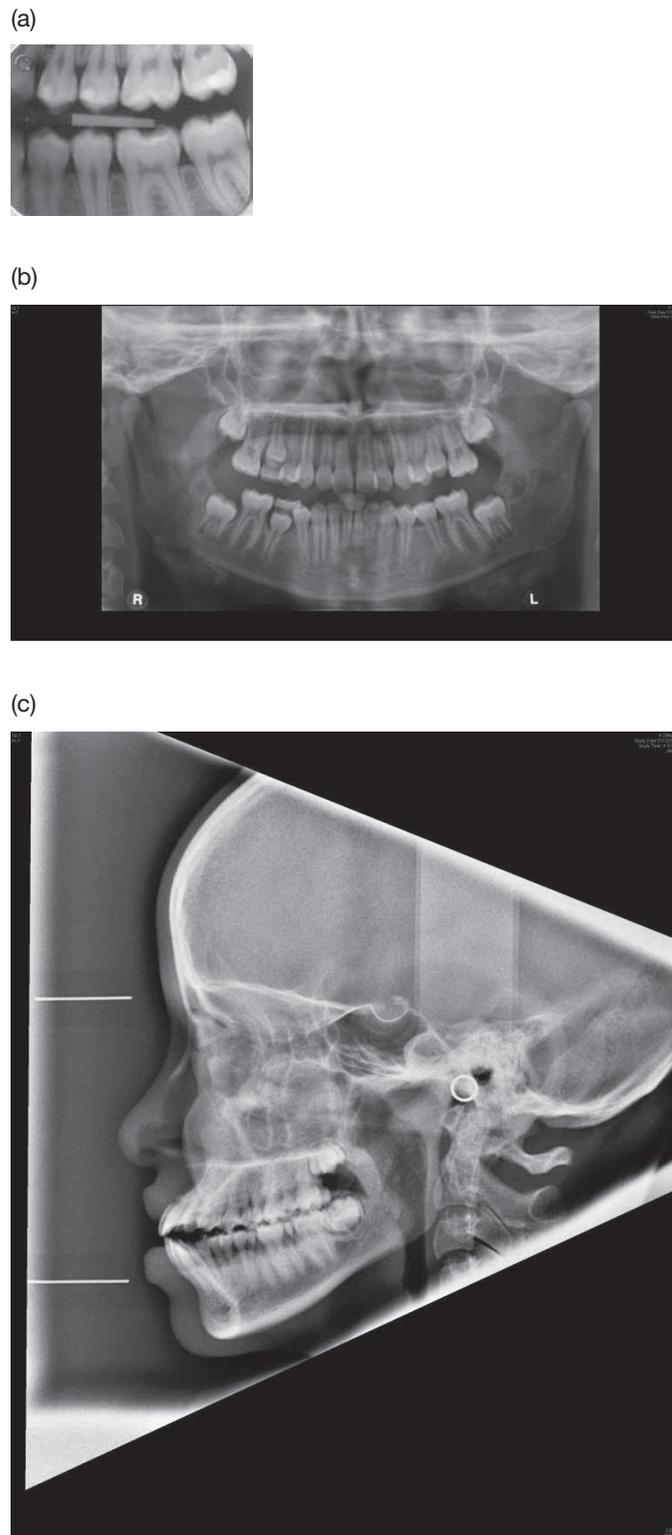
Traditional dental radiographs: (a) bitewing, (b) panoramic, (c) lateral cephalometric radiographs.
